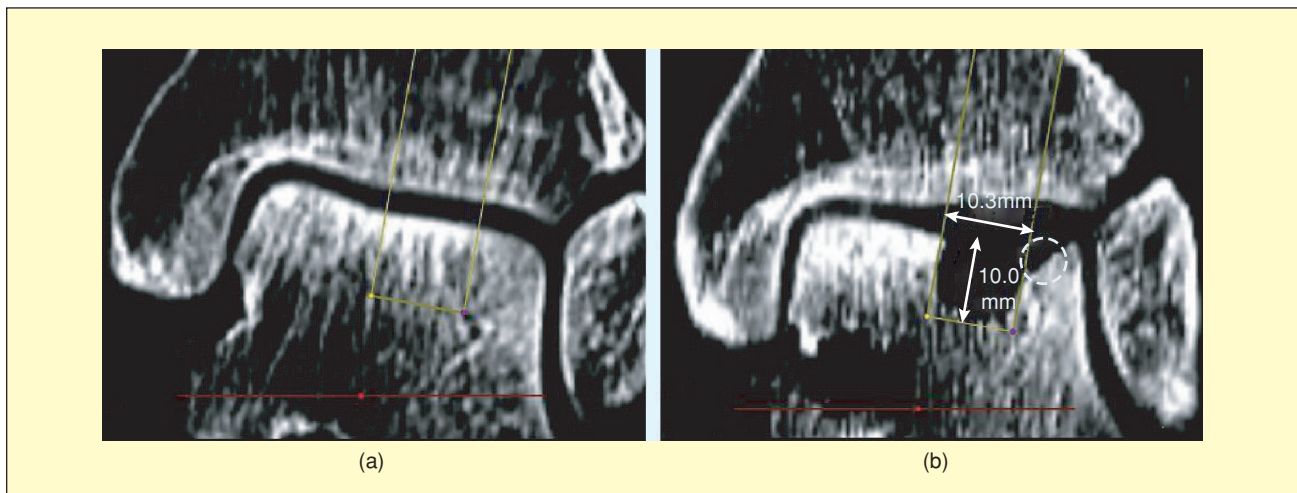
The dorsal view of the operative result: (a) planned profile and (b) postoperative CT with damaged edge (encircled).
